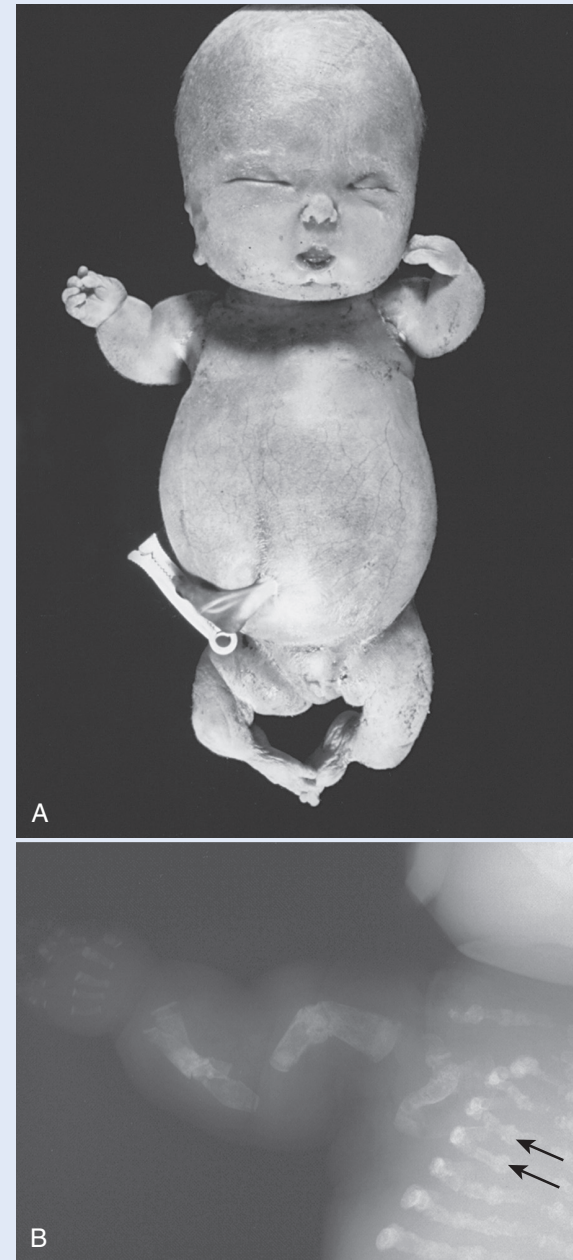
A, A stillborn infant with type II osteogenesis imperfecta (the perinatal lethal form). The infant had a type I procollagen mutation and short, slightly twisted limbs. B, Radiograph of an infant with type II osteogenesis imperfecta. Note calluses from rib fractures, which are observable as “beads” on the ribs (arrows).
